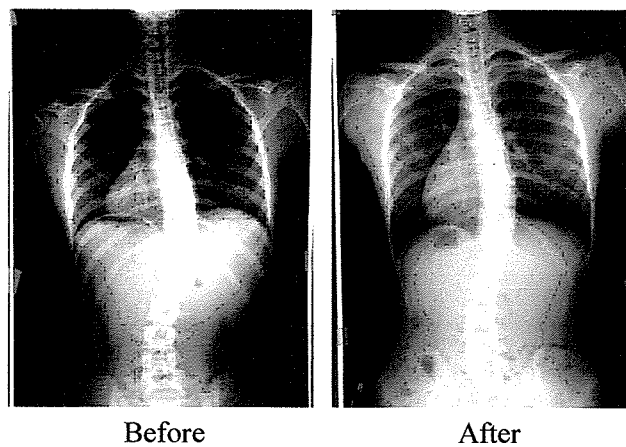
The pre and post X-ray pictures of subject C
